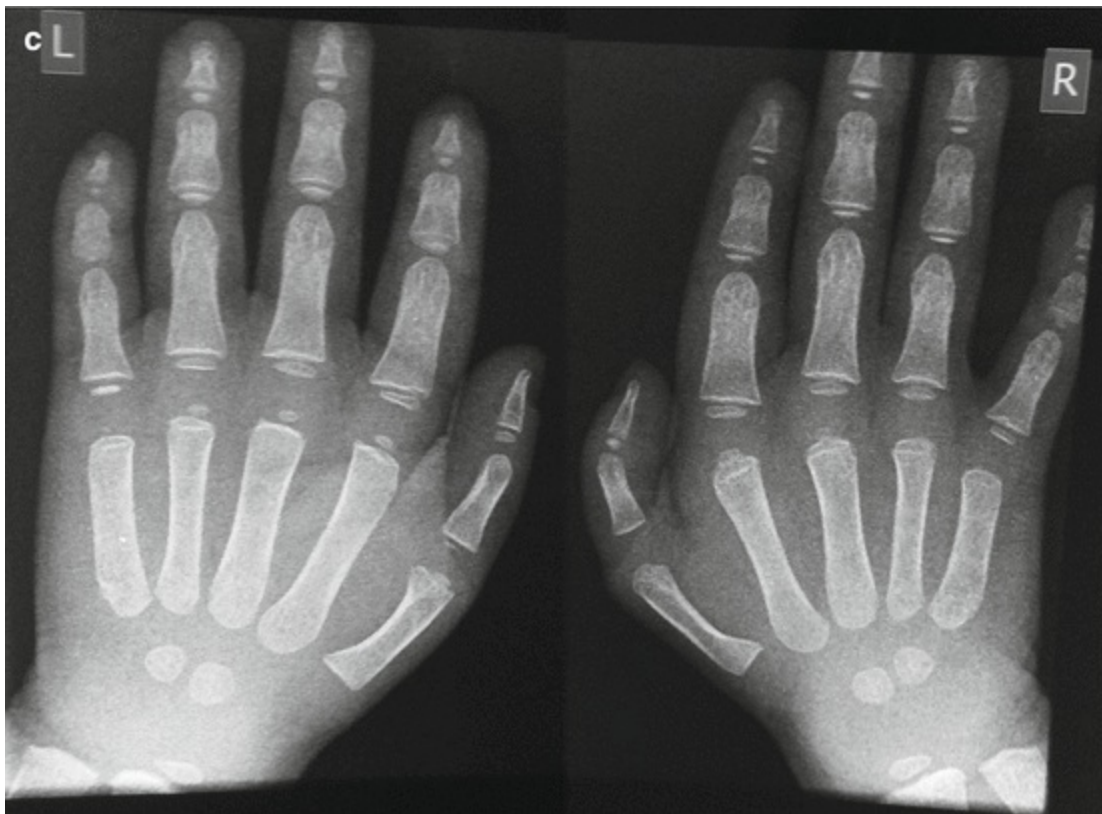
Thumb clinodactyly: (a, b) clinical appearance; (c) radiography of both thumbs revealed right thumb congenital anomaly
